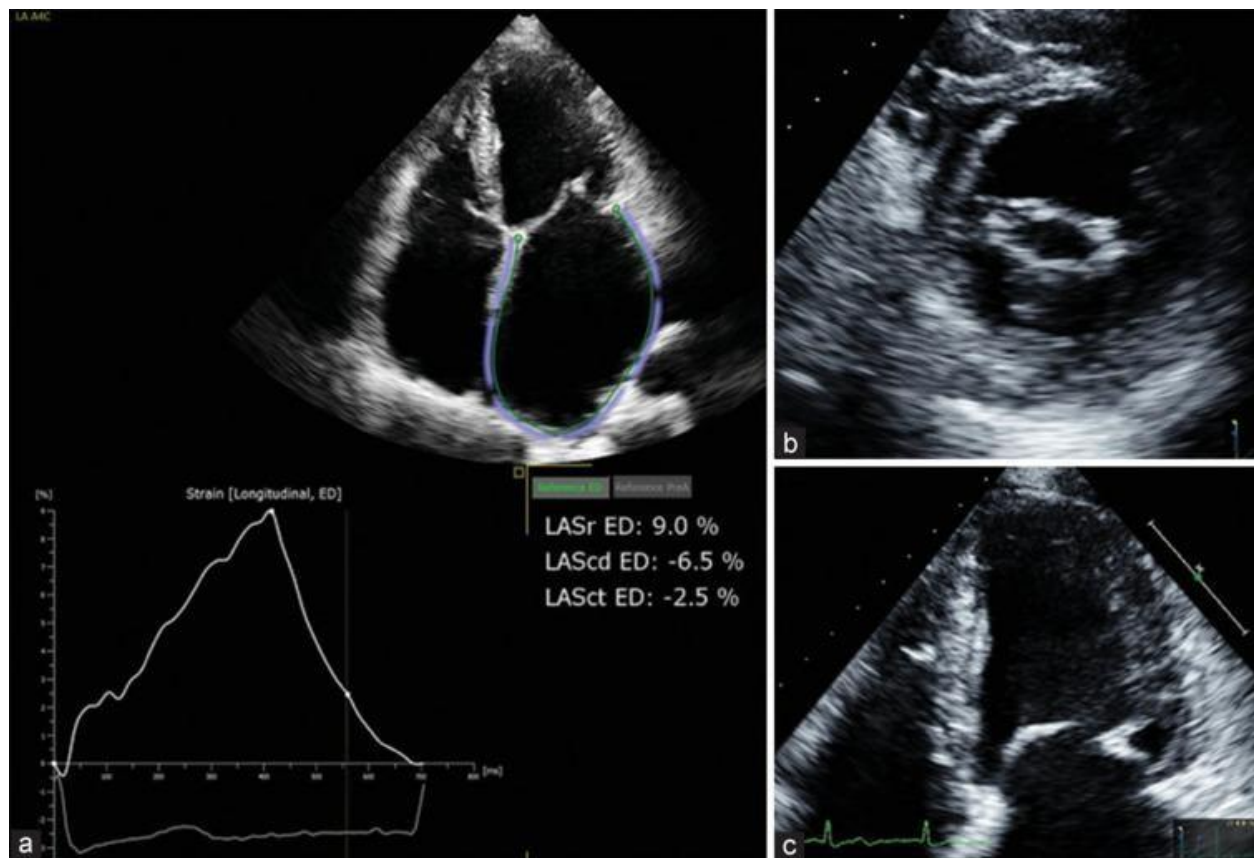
Example of patient with moderate-to-severe mitral stenosis; (a) Left atrial strain (LAS) curve and values in all phases showed marked reduction of LAS-reservoir, LAS-contrastile, and LAS-conduit, (b) Two-dimensional echo showing mitral valve orifice in short-axis view, and (c) Apical four-chamber view showing doming of both mitral valve leaflets with restricted opening. LAS-r = Left atrial strain reservoir, LAS-cd = Left atrial strain conduit, LAS-ct = Left atrial strain contractile
